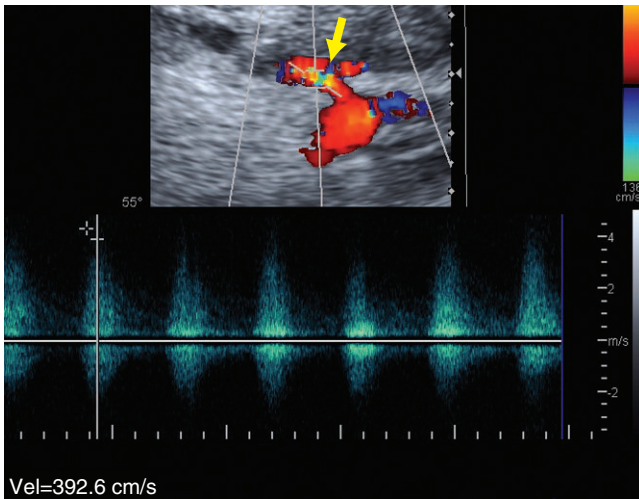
The color Doppler image immediately distal to the origin of the transplant renal artery shows aliasing (arrow) and a markedly elevated peak systolic velocity (393 cm/second).
